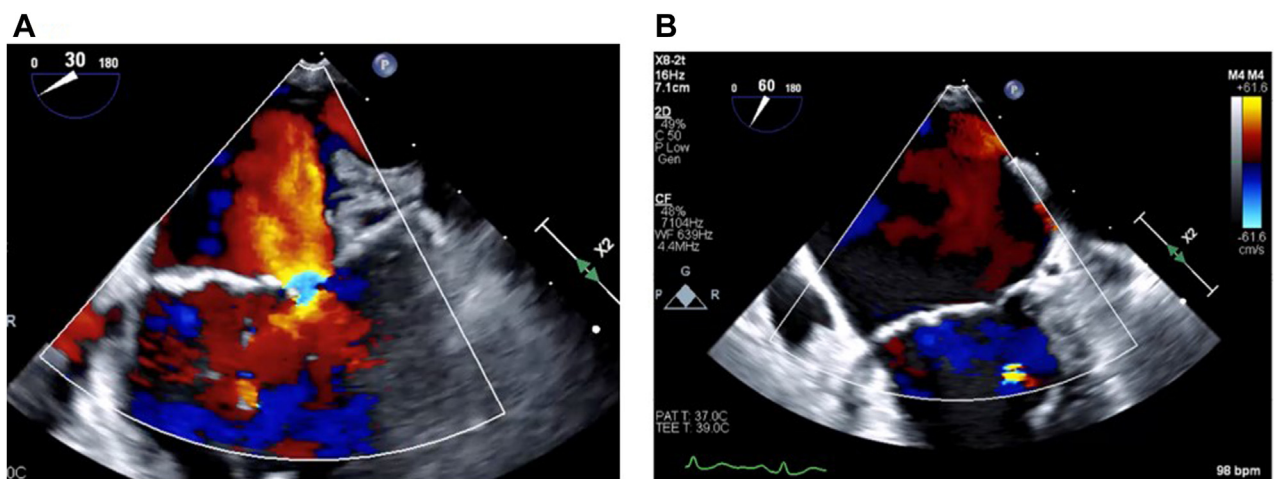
Two-dimensional TEE, midesophageal 4-chamber (A: 30°) and (B: 60°) systolic zoom views with color-flow Doppler, demonstrates mild MR.
